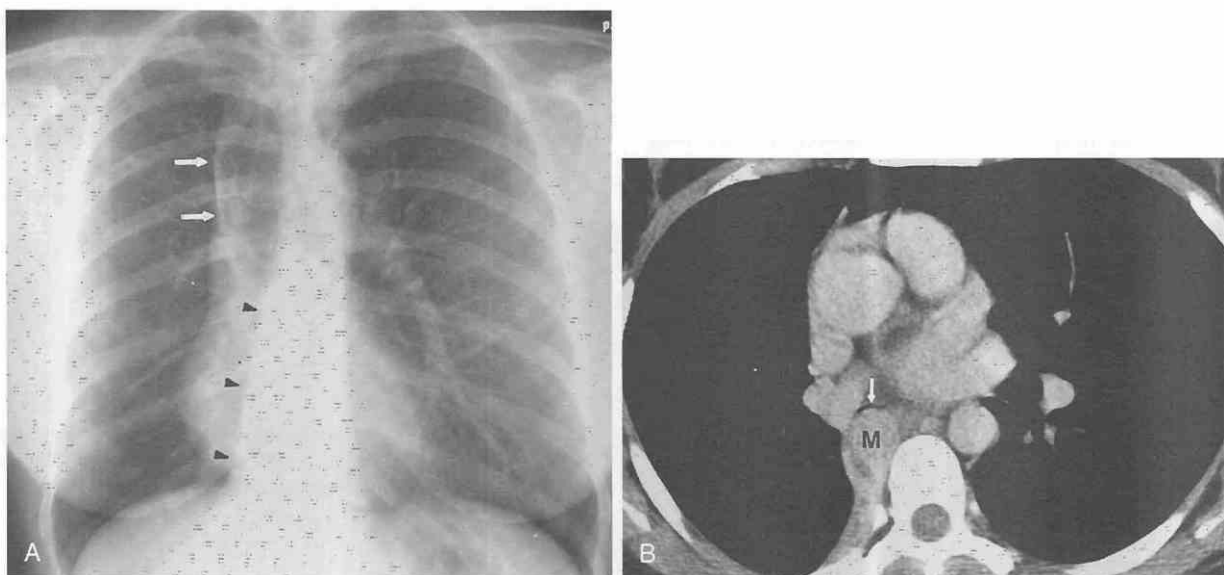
Typical carcinoid appearing as a central endobronchial lesion. *A*, Posteroanterior chest radiograph shows complete atelectasis of right lower lobe (arrowheads) with compensatory hyperinflation of the left lung. Note the displacement of the anterior junction line (arrows). *B*, CT confirms atelectasis of the right lower lobe and reveals an endobronchial mass (M) with marked narrowing of the bronchus intermedius (arrow).
